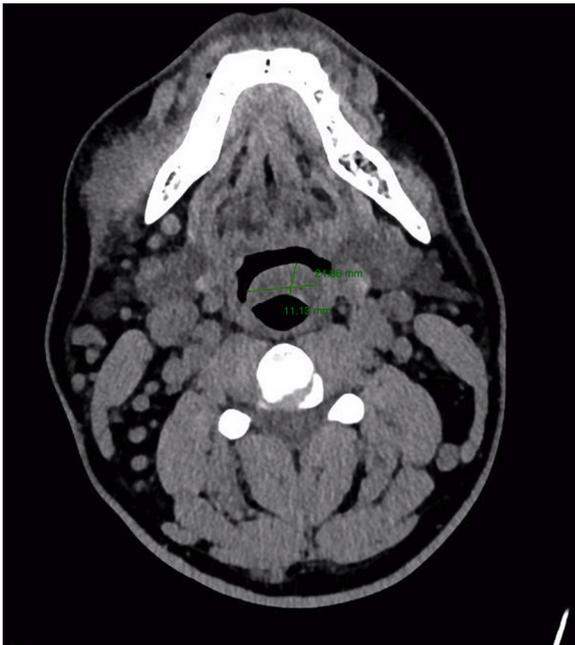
CT scan of the neck showing a large soft tissue tumor (greatest dimensions: $48 \times 36 \times 24$ mm) in the right mandibular region, together with unexpected thickening of the epiglottis (11×25 mm).
